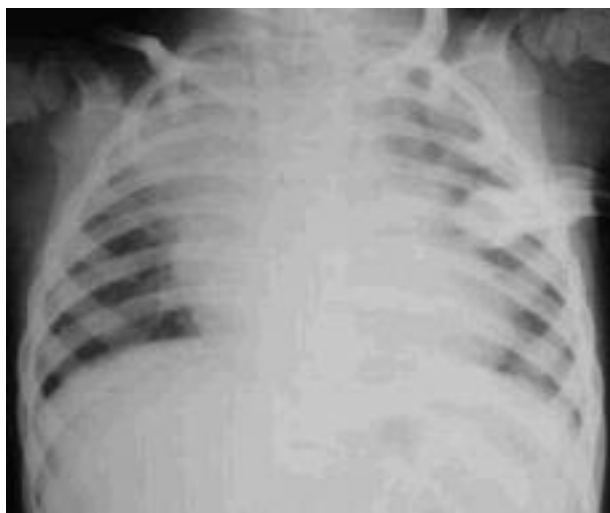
Chest radiograph revealing areas of consolidation in the right upper lobe consistent with aspiration.
